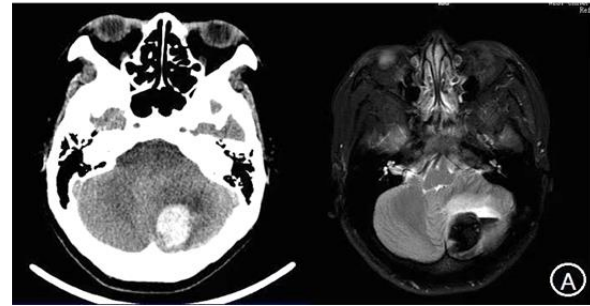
Brain Computed Tomography (CT) of patient #1
